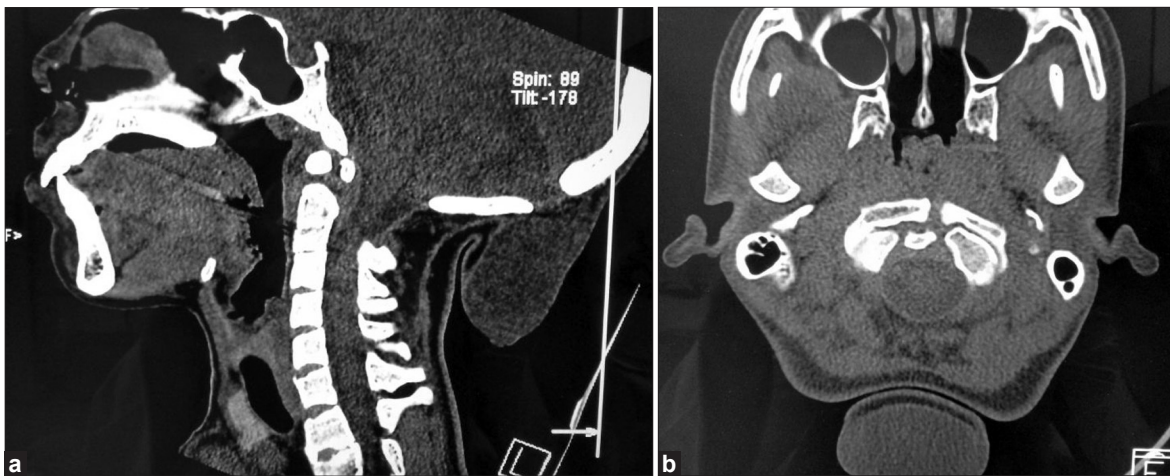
(a) Sagittal and (b) axial view CT CV junction show OS terminale and encephalocele with bone defect
